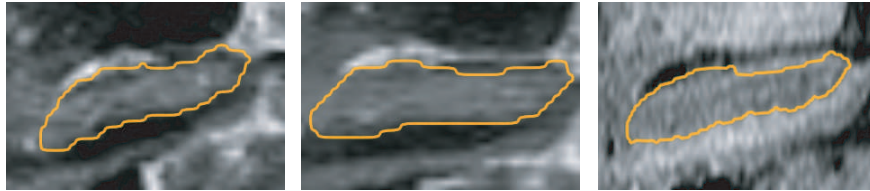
An example of the automated segmentation of the hippocampus in a sagittal plane for all three examinations of the same subject. From left to right are shown a baseline HASTE MRI scan (absolute volume 4.0 ml), the first follow-up HASTE MRI scan (absolute volume 3.9 ml), and the second follow-up T1-weighted scan (absolute volume 3.1 ml).
